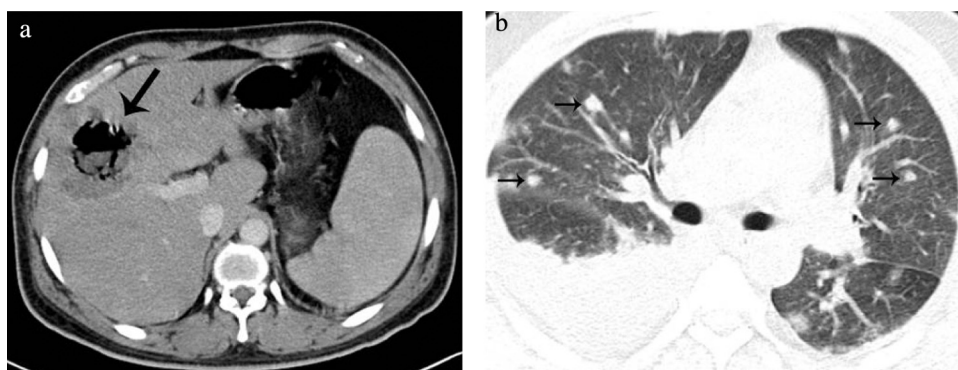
Images of a 59-year-old man with diabetes who presented with fever for 3 days. (a) Contrast-enhanced CT showed a single abscess with gas formation in the right lobe of the liver (arrow). Abscess cultures were positive for *K. pneumoniae*. (b) Multiple nodules (arrows) and right pleural effusion were visible on the chest CT.
